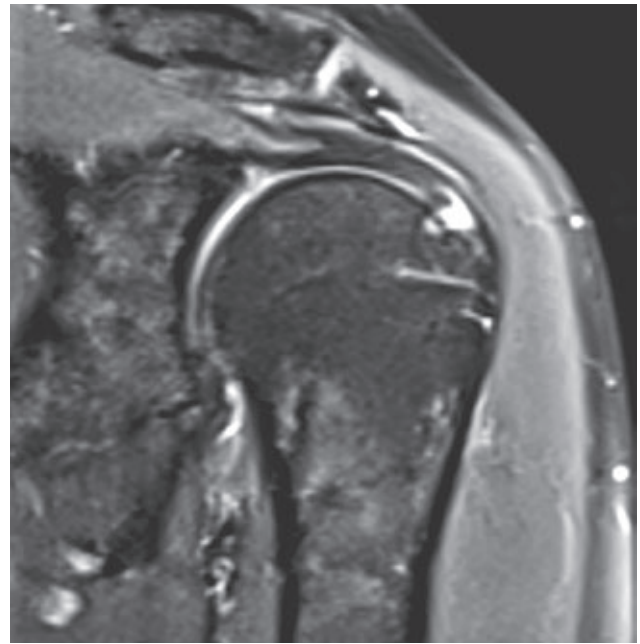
Example of an articular surface tear (grade IIIA) from a T2-weighted oblique coronal section.
